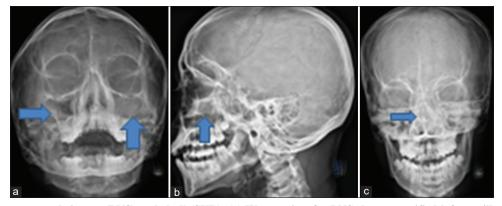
Plain X-rays paranasal sinuses (PNS) and skull (SXR). (a) Waters view for PNS shows opacified left maxillary sinus (vertical blue arrow) and mucosal hypertrophic lining in the right maxillary sinus (horizontal blue arrow). (b) SXR lateral view shows superimposed opaque sinuses (vertical blue arrow). (c) Anteroposterior view of SXR shows deviated nasal septum to the right (horizontal blue arrow)
